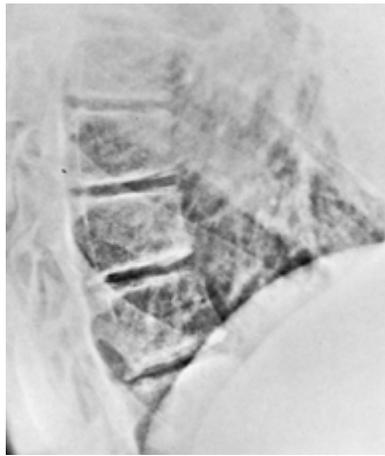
Lateral spine radiograph demonstrating the disc irregularities and anterior vertebral body wedging seen in Scheuermann disease.
